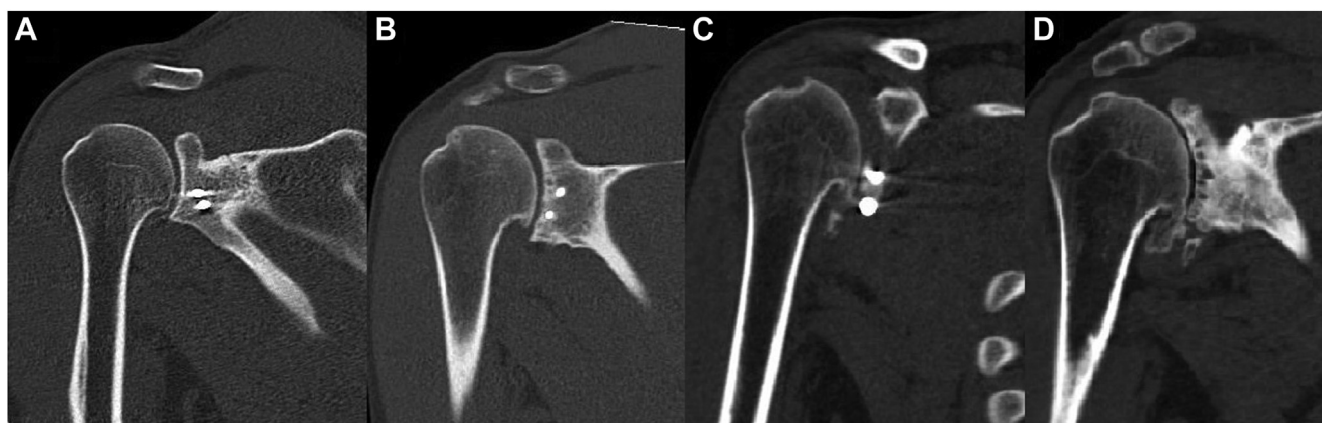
Postoperative osteoarthritis classified using the modified Samilson-Prieto classification system, with assessment performed through CT scans. (A) Grade 1: indicated by an inferior humeral spur, measuring less than 3 mm in height. Humeral heads with the margin making an acute angle or being associated with the addition of sclerotic bone are classified into this grade, even if no obvious spur formation is present. (B) Grade 2: indicated by a spur measuring between 3 and 7 mm. (C) Grade 3: indicated by a spur exceeding 7 mm. (D) Grade 4: complete obliteration of the glenohumeral joint space with or without osteophytes. CT, computed tomography.
